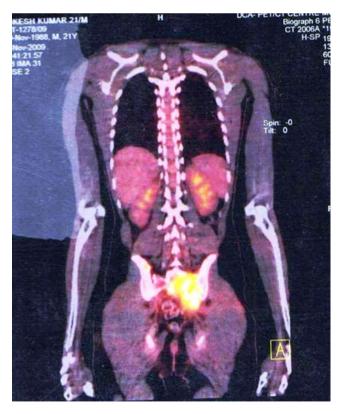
PET-CT image showing FDG avid lesion indicative of a pelvic STS $% \left({{{\rm{STS}}}} \right)$
